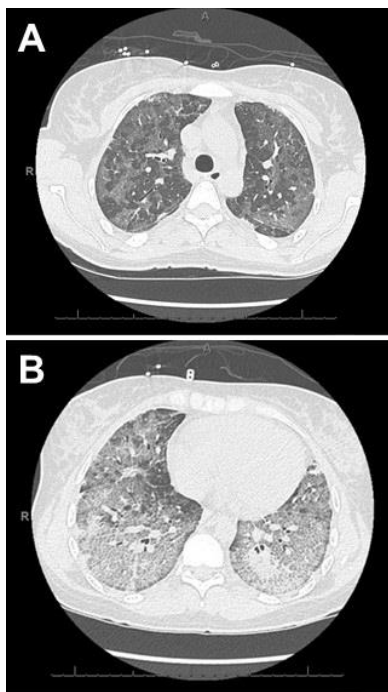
Representative lung windows from thoracic CT scan.
